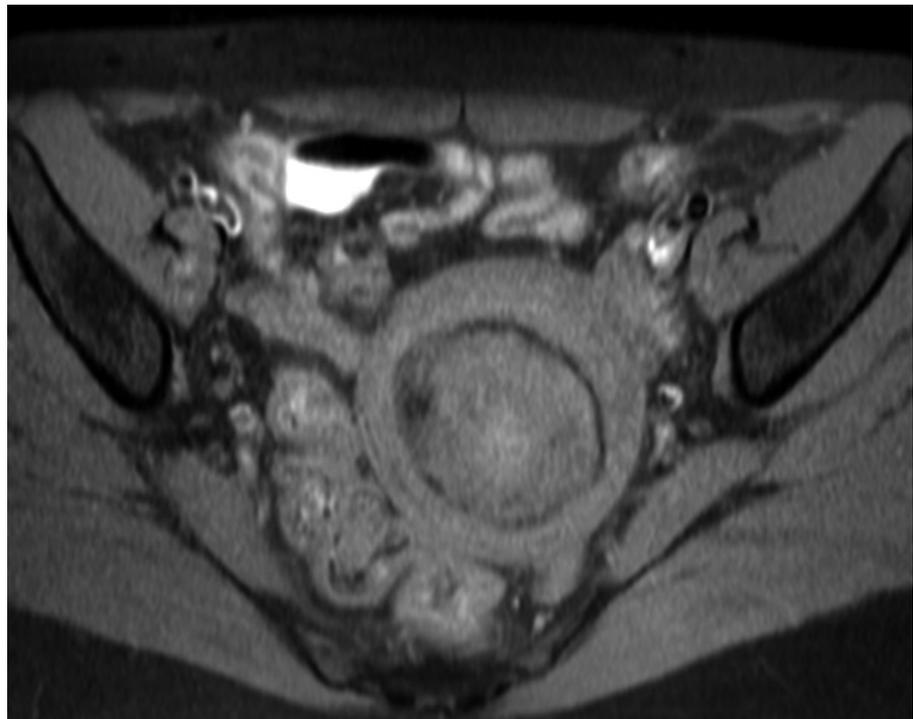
MRI of rim calcification of a leiomyoma. T1-weighted fat-suppressed transaxial image showing a leiomyoma with a discontinuous, markedly hypointense rim corresponding to asymmetrical calcification
